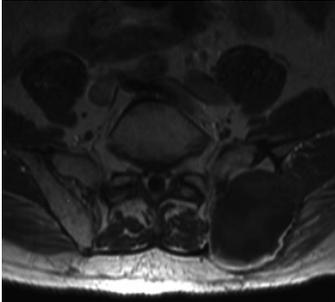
MR control ,thyroid cancer with bone metastasis. Iodine 131 can not be used (too large tumor). Radio frequency ablation of the tumor with 90% of the tumor coagulated (see MR imaging). The Radio-frequency ablation was followed by Iodine 131 therapy. Complete ablation of the tumor.
